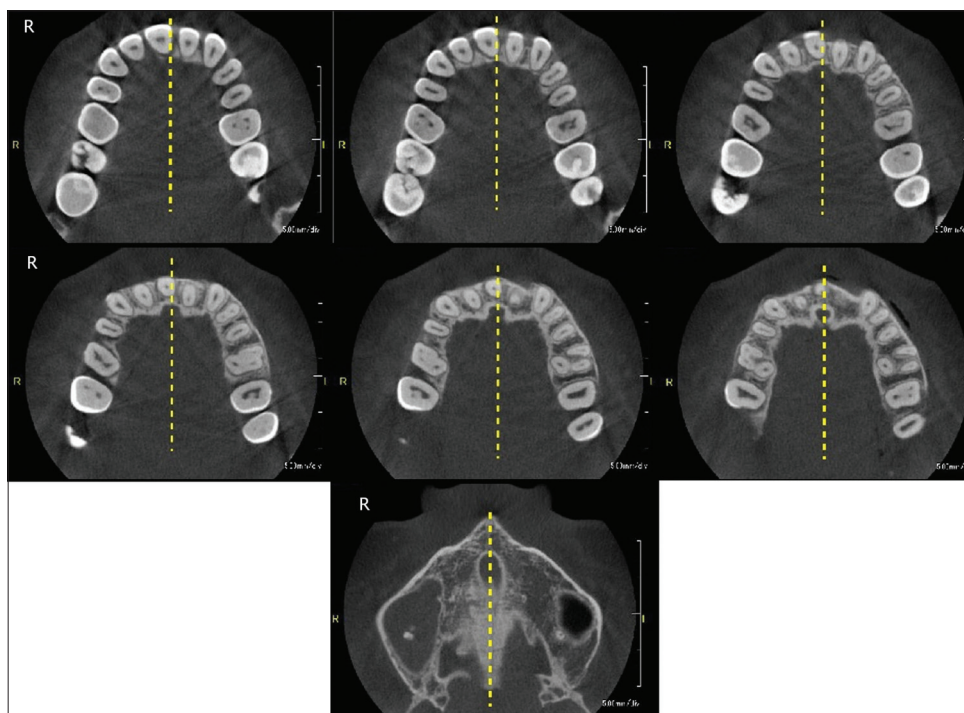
Representative cone-beam computed tomography images of the maxilla in the horizontal plane from the crown to the apex of the maxillary left central incisor (from the left of the upper row to the right of the middle row). We determined the midpalatal suture (MPS) in the image immediately beneath the nasal floor (yellow broken line in the bottom image). The MPS indicated by the yellow broken line was then transferred to the other images. R: Right.
